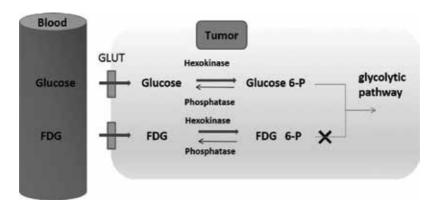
Mechanism of FDG uptake. Like glucose, FDG is taken up by cells via glucose transporters and phosphorylated; however, unlike glucose, FDG remains in cells after phosphorylation.
